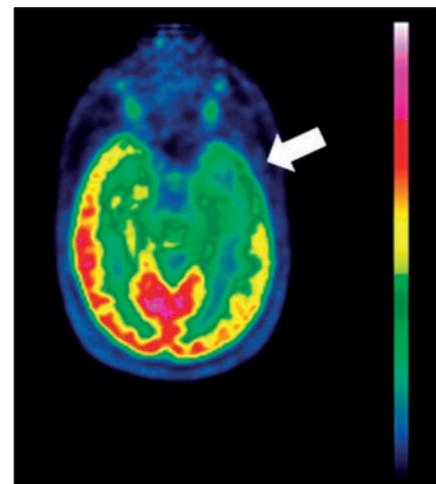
An FDG-PET study in a patient with an epileptogenic focus in the left temporal lobe. The scan shows widespread hypometabolism in this lobe, more extensive than that in the epileptogenic focus alone.
